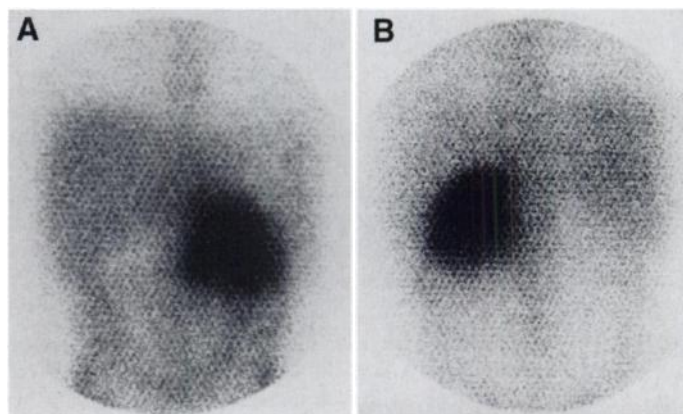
Gallium images. (A) Anterior and (B) posterior images of the abdomen from a whole-body gallium scan show a large left upper quadrant focus of intense increased radiotracer uptake corresponding to the CT finding.
